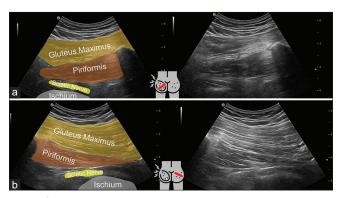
Ultrasound images of the posterior hip showed increased thickness, loss of perimysium, and blurred border of the left piriformis muscle (a). Normal side (b)
